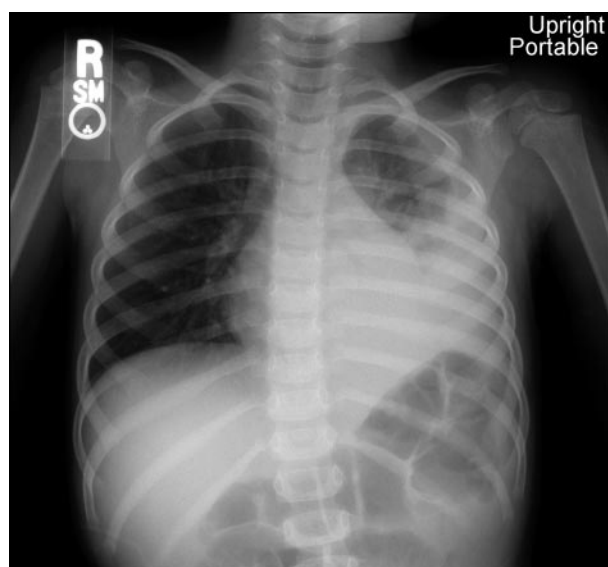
Radiographic findings of pneumococcal empyema: Left lower lobe and lingular consolidation (note loss of the left hemidiaphragm and lower left heart border) with associated large left pleural effusion tracking up laterally. Volume loss on the left also indicates a component of atelectasis.
